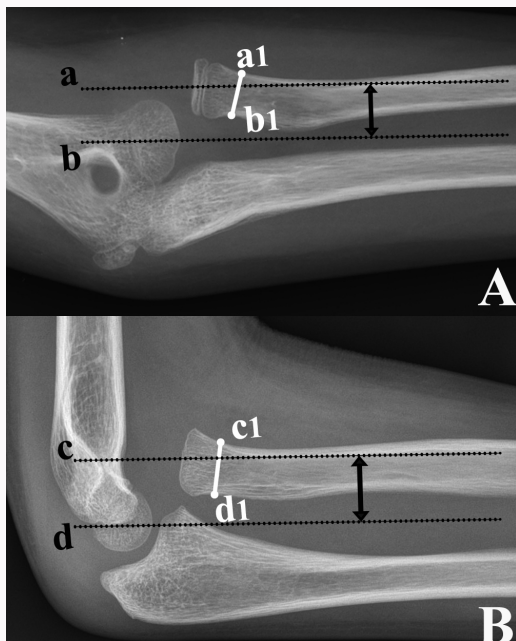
Radial head elevation, measured on anteroposterior (A) and lateral (B) radiographs, is expressed as the ratio of the distance between the lines passing through the centre of the proximal radial metaphysis (a and c) and the centre of the humeral capitellum (b and d) to that of the narrowest width of the radial neck (a1 to b1 and c1 to d1).
